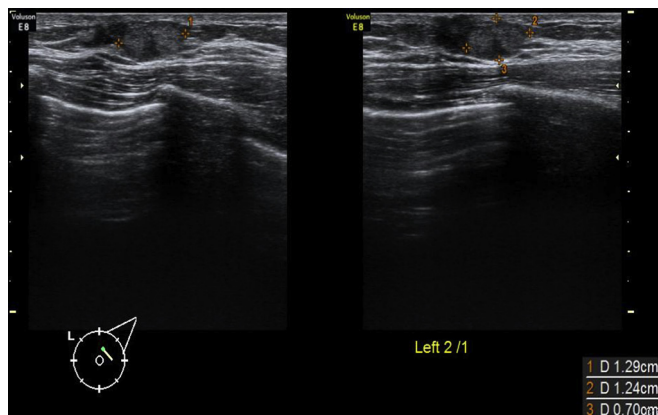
Breast sonography reveals a 1.3 cm well defined tumor in left upper outer breast retroareolarly.
